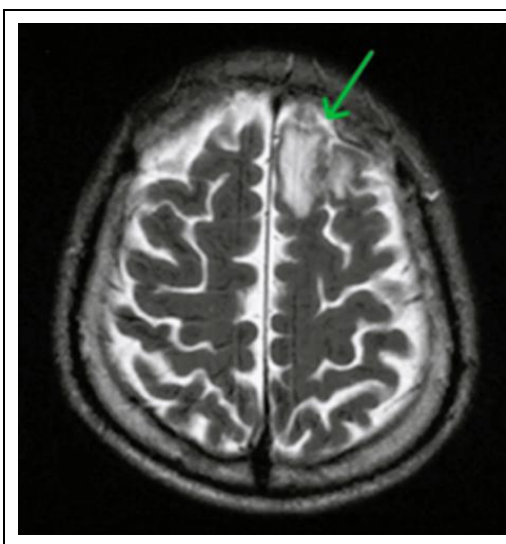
Example of a T2-weighted brain MRI demonstrating a hypertense signal with surrounding edema (green arrow) in the frontal parameian cortex seen in patient with primary CNS lymphoma. Adapted from MRI imaging features of HIV-related central nervous system diseases: diagnosis by pattern recognition in daily practice.
